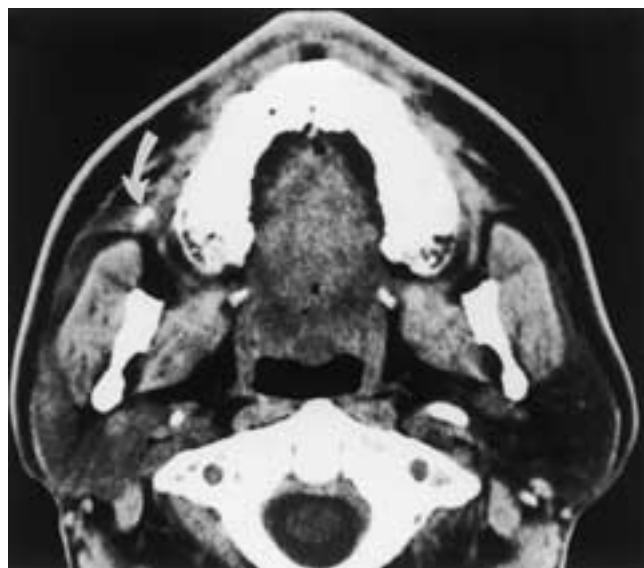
Calculus in the right parotid duct. Axial noncontrast-enhanced CT scan demonstrates a small calculus in the distal portion of Stensen's duct (*arrow*). Dilated intraglandular ducts are not identified on this image. However, the attenuation of the right parotid gland is higher than that of the normal left parotid gland. This reflects congestion, edema, and/or infection. (Courtesy of Dr. Deborah Reede.)
